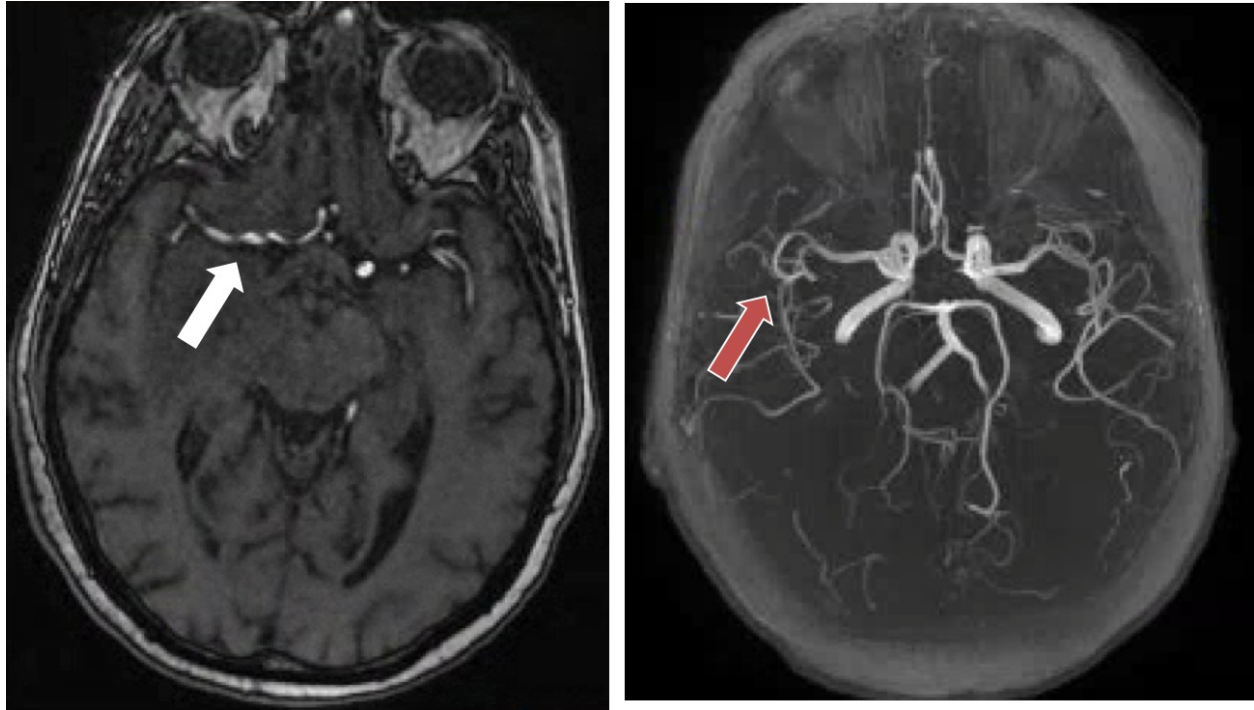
3-D reconstruction of MRI at the Time of Presentation: Repeat MRI at the time of presentation to geropsychiatry demonstrated no focal narrowing or cutoff of cerebral vessels, to suggest an acute vasculitic episode. Distal right Middle Cerebral Artery branches remained reduced/absent, consistent with MRI one year prior.
